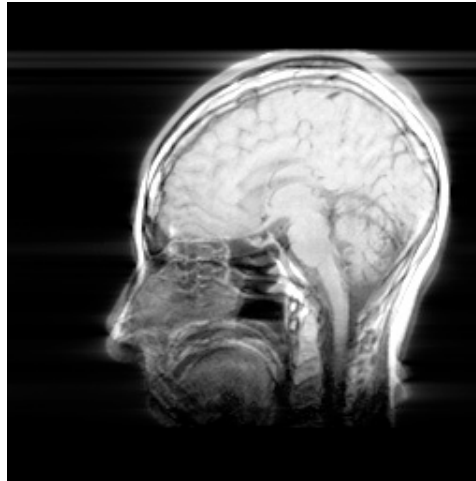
Brain DCE-MRI showing some motion artifacts
